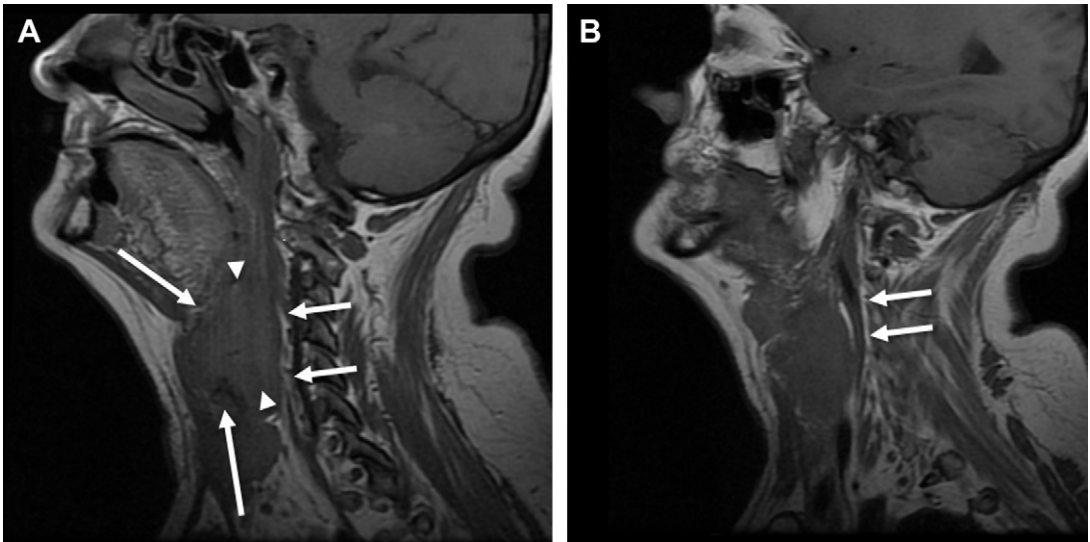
Parasagittal (A) and further lateral parasagittal (B) T1-weighted MR images of bulky laryngohypopharyngeal tumor. Note bulky tumor involving both larynx (*long arrows*) and hypopharynx (*arrowheads*). Fat stripe is preserved (*short arrows*), implying no involvement of the retropharynx or prevertebral fascia.
